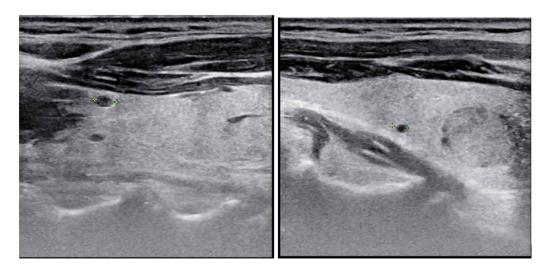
Thyroid ultrasound after 5 months.
